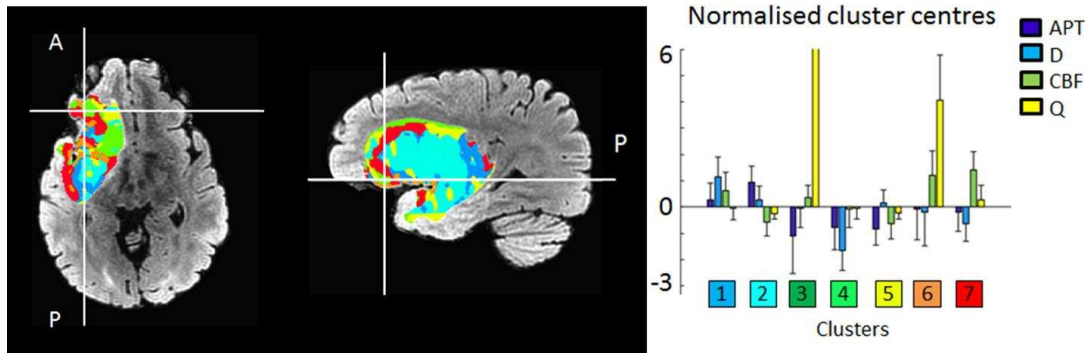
Example of using advanced MRI biomarkers to map the heterogeneous microenvironment of non-enhancing glioma. Left: Overlay of 7 different types of tissue within the tumour on axial and sagittal cross-sections of a T₂-weighted FLAIR image. Tissue types are determined based on a clustering algorithm with advanced MRI biomarkers as input and are characterised on the right. *APT: Amide proton transfer ratio, D: Diffusion coefficient, CBF: Cerebral blood flow, Q: Vessel density, A: anterior, P: posterior.*
